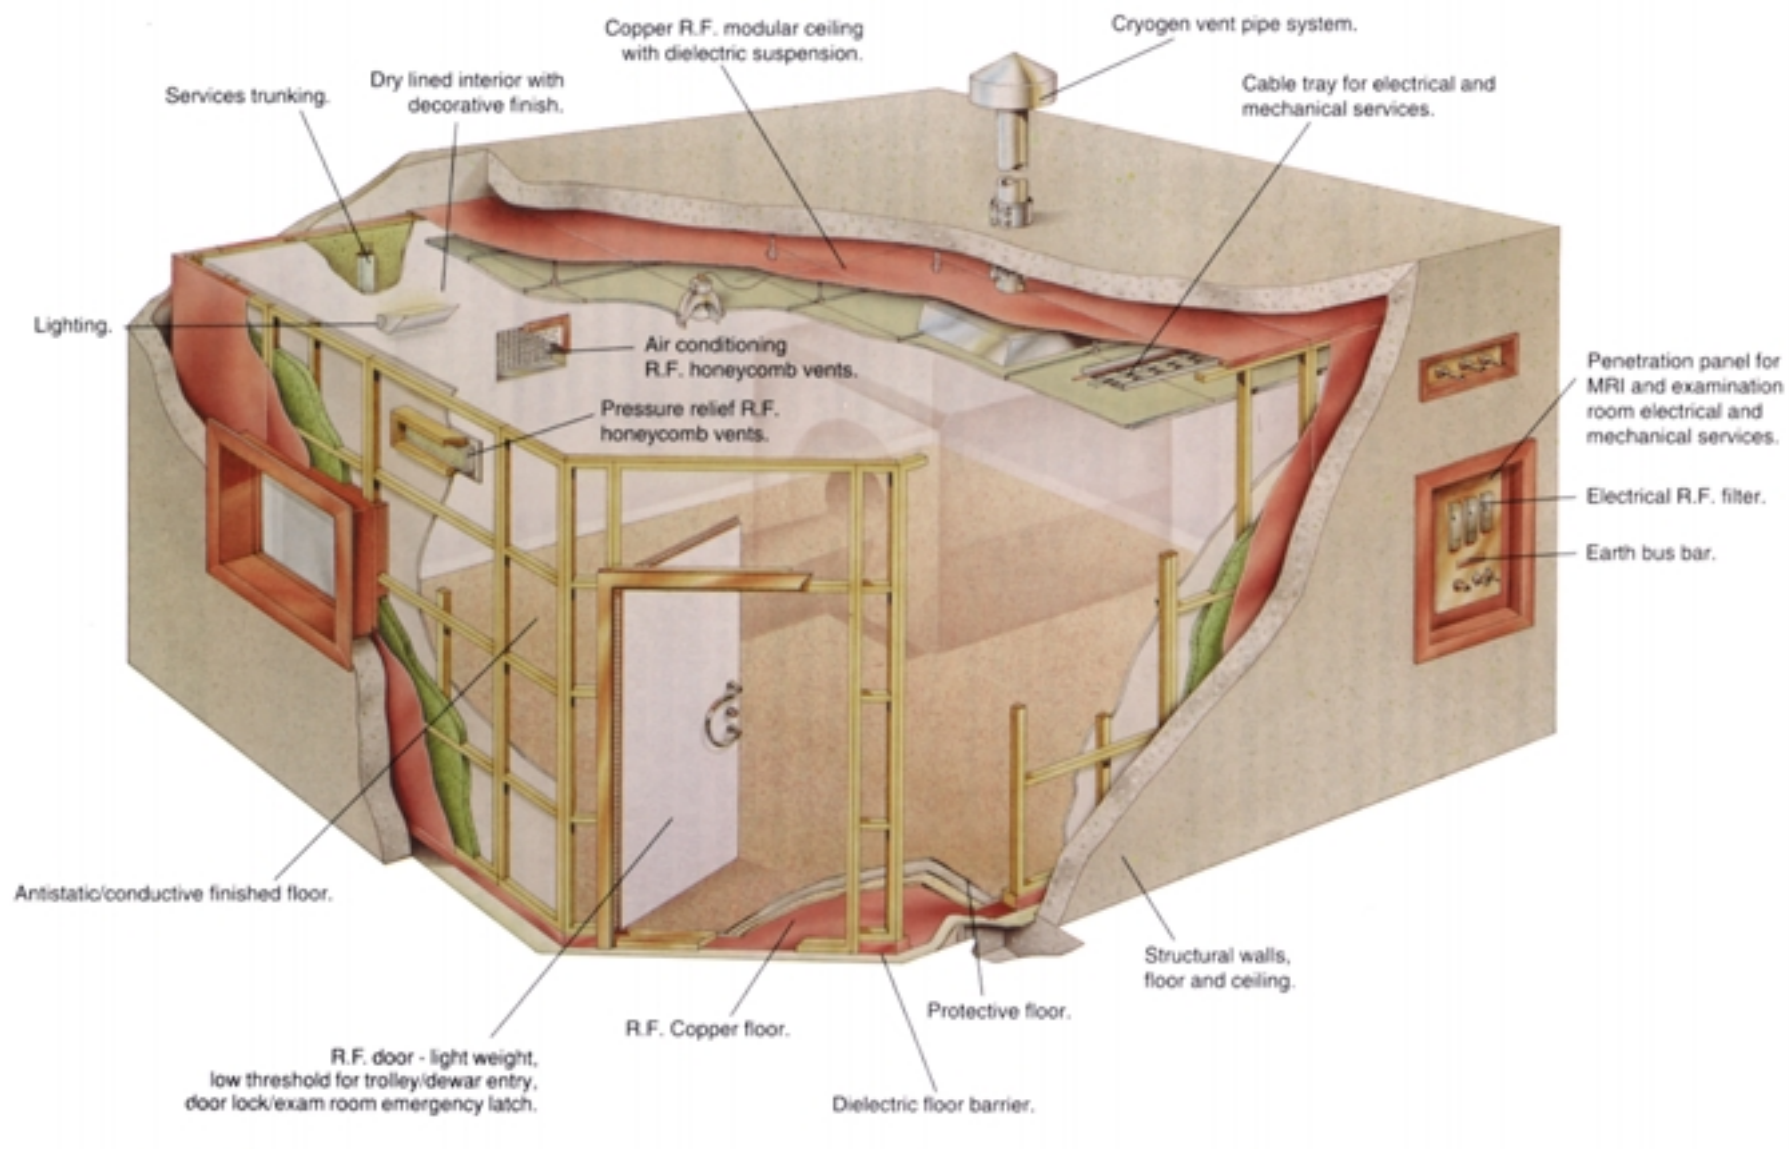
Image of a typical MRI scanner room.
